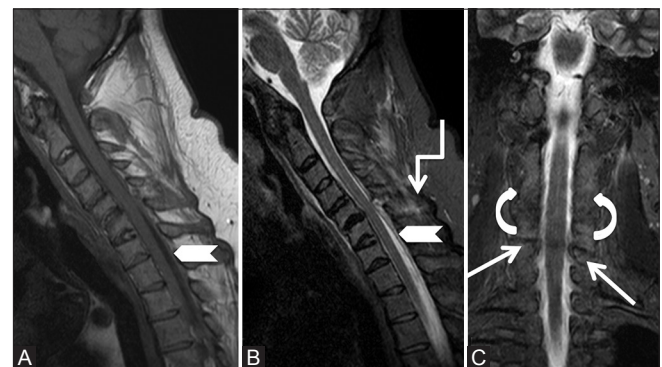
(A-C): Miscellaneous: Post-traumatic epidural hematoma: 43-year-old male with a known history of ankylosing spondylitis had a trivial fall followed with severe cervical region pain. Sagittal T1-weighted (A), T2-weighted (B) and short T1 inversion recovery (C) images showing loss of cervical lordosis, syndesmophytes along vertebral bodies, as well as osseous fusion of facets on both sides (curved arrow). Posterior epidural soft tissue is seen from C4-T1 levels (arrowhead) indenting on the cord and fracture is seen through C5-6 facet joint (arrow). Edema is seen in interspinous soft tissue (elbow arrow)
